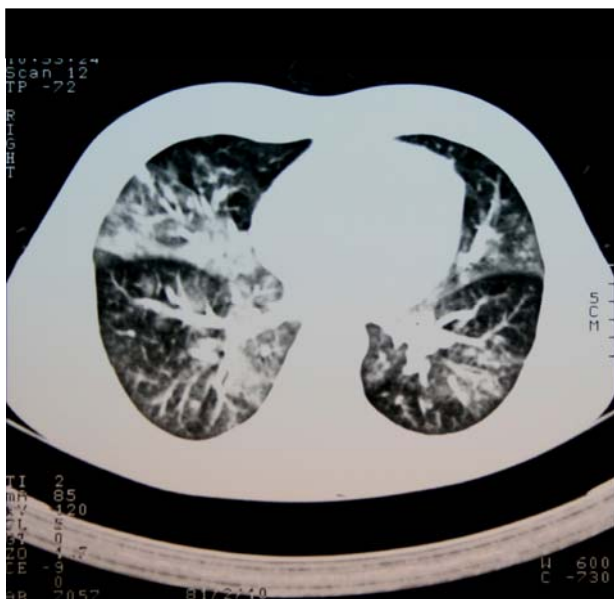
High resolution CT image demonstrates marked peribronchial and perivascular thickening with patchy ground glass opacity.
